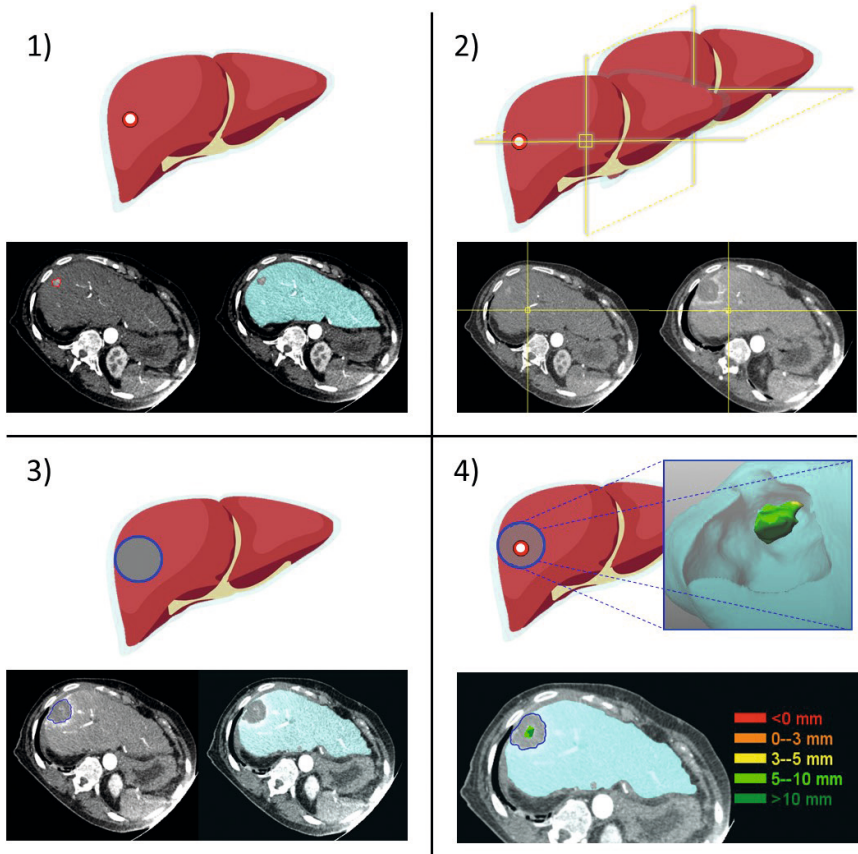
Software assisted ablation margin quantification. 1: Semi-automatic segmentation of the liver and manual segmentation of the liver tumor. 2: Semi-automatic grey-scale based rigid registration of pre- and post-ablation CT scans. 3: Semi-automatic segmentation of the ablation zone. 4: Analysis of quantified ablation margins.
